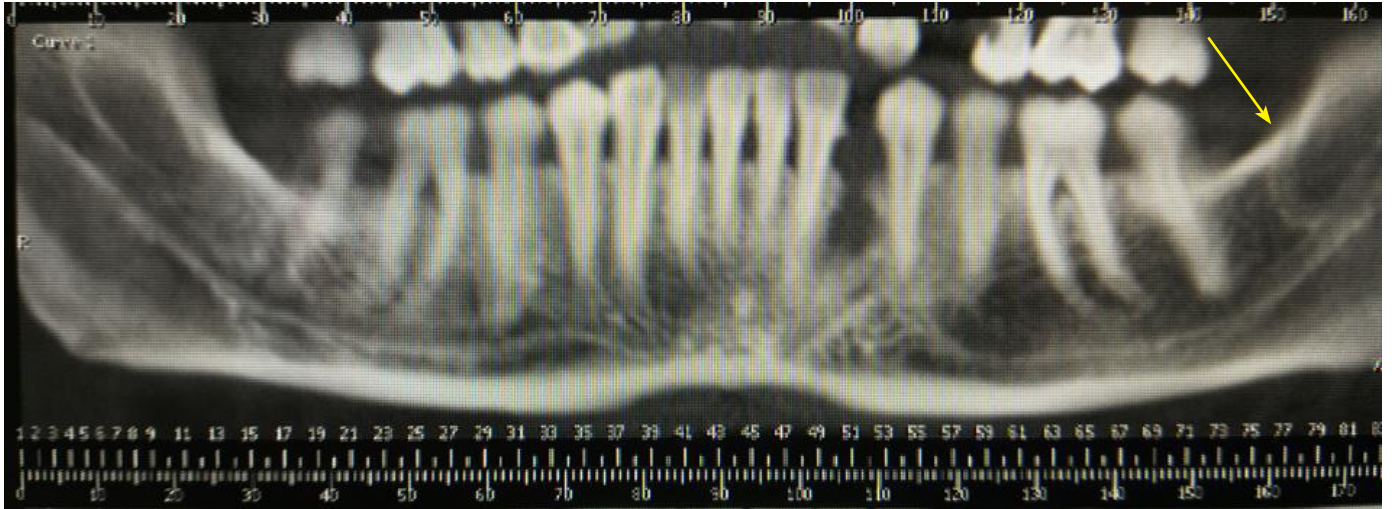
X-ray of lower arch.
